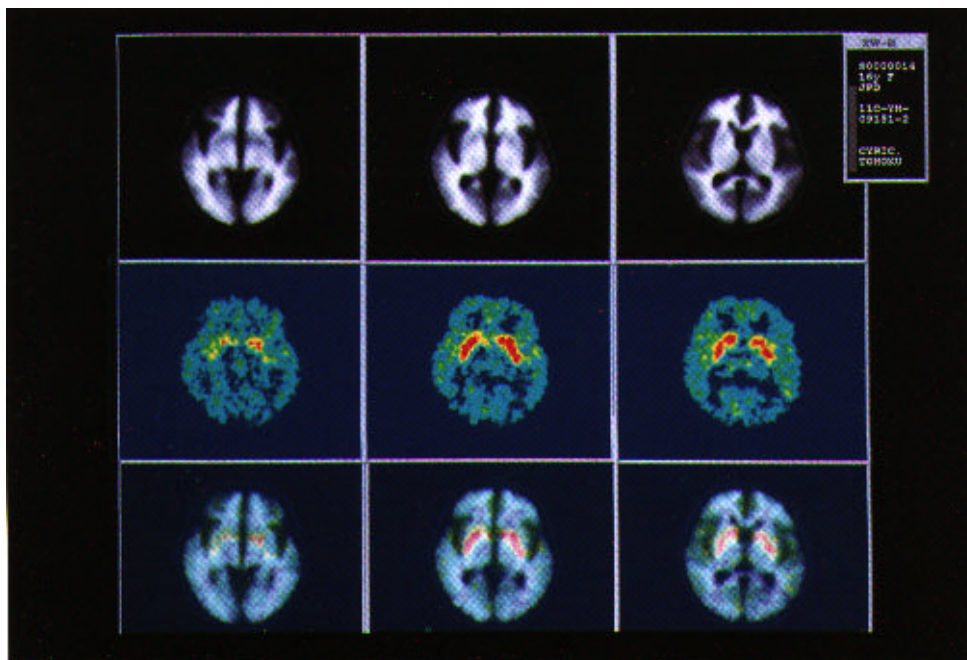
Aligned MR images, PET images added between 60 and 90 min after administration of ¹¹C-YM and the overlapped images at the same brain slices, of this patient with JP. ¹¹C-YM was highly accumulated in the caudate nucleus and the putamen on both hemispheres, which indicated no decrease of dopamine D2 receptor binding in the striatum.
